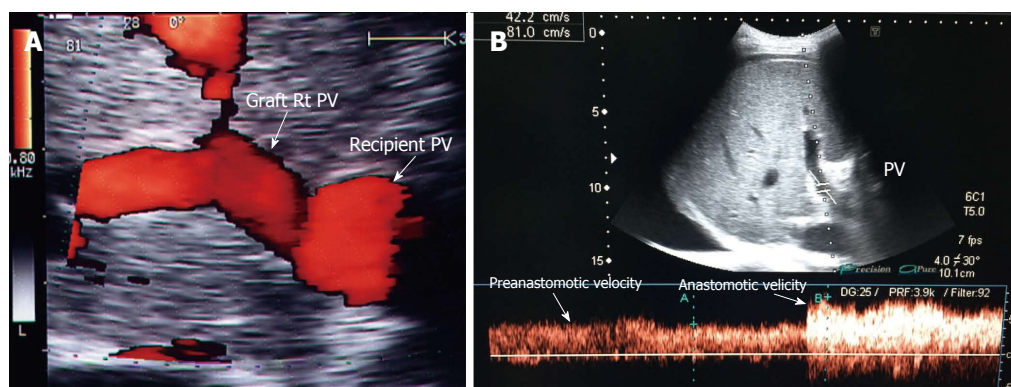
Portal vein size mismatch in right lobe grafts. A: Post-operative color ultrasound image showing size mismatch between the recipient and donor PVs, a frequent finding in right lobe living donor liver transplantation; B: Color Doppler image showing anastomotic augmentation of the PV velocity (2-fold) compared to the pre-anastomotic velocity (accepted finding in the presence of size mismatch). PV: Portal vein.
